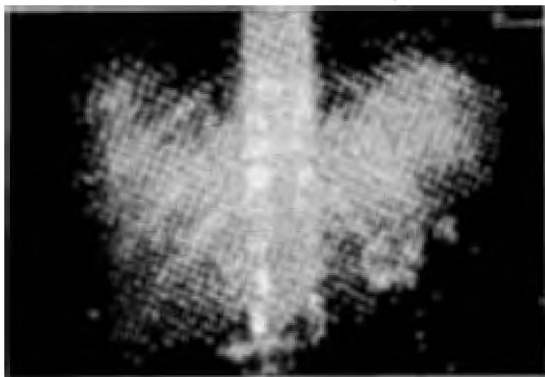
Extensive pancreatic calcification seen in straight X-ray of abdomen in Case 6.
